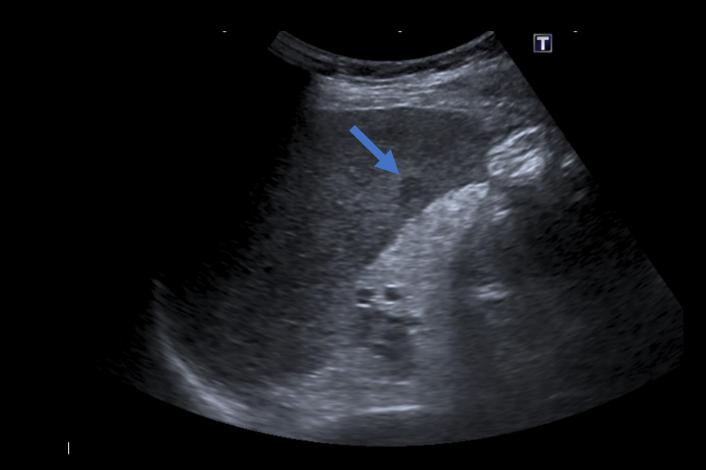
Ultrasound. Focal hypoechoic nodule.
